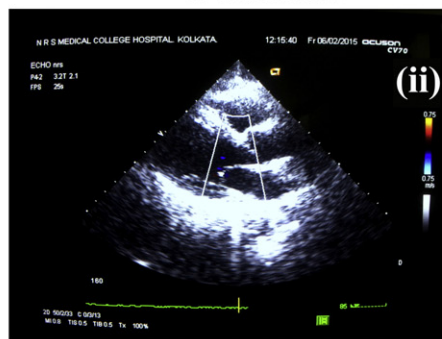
A representative Echocardiogram of a DCM patient and a control subject. ECHO for the patient sample showed the dilation of LV and presence of mitral regurgitation and global hypokinesia.
